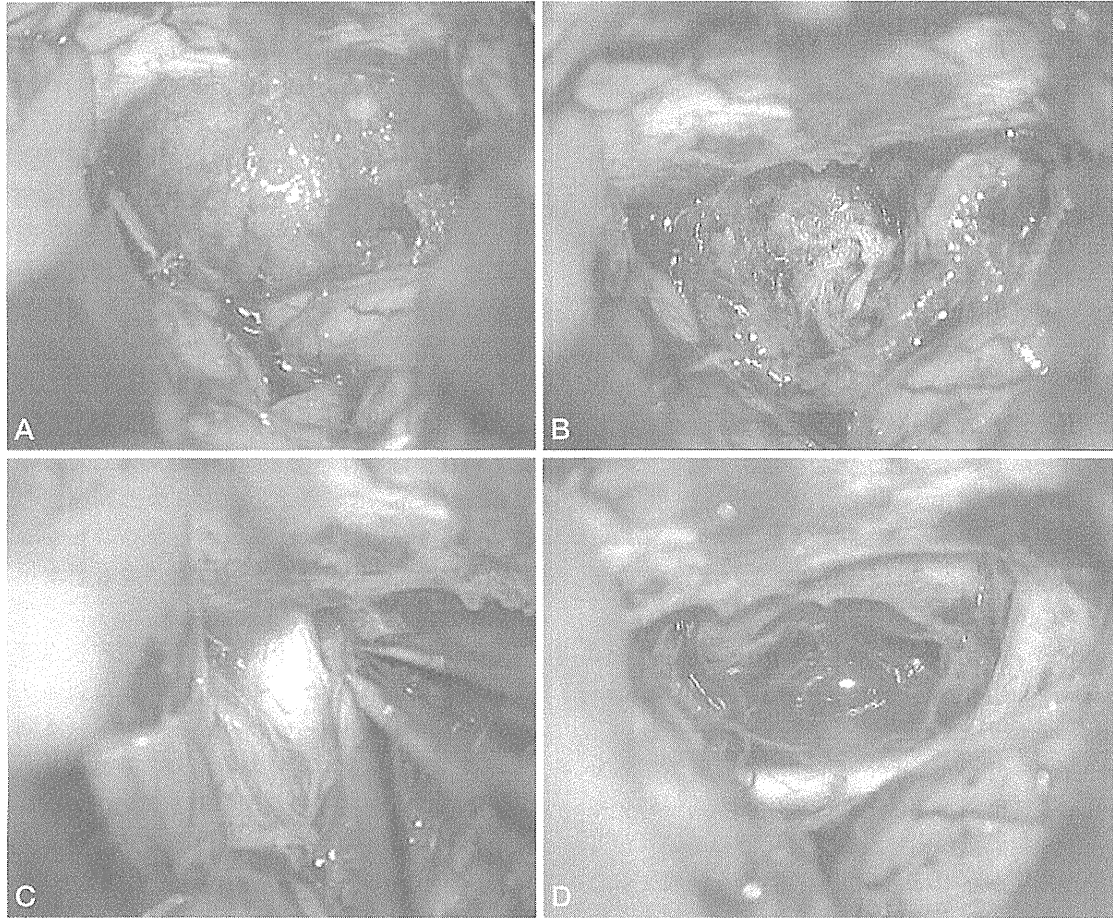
A: After dissection of the anterior interhemispheric fissure, the tumor was exposed in the center of the surgical field. B: The tumor was first detached from its origin with bipolar cautery and debulked with an ultrasonic aspirator. During this step, main tumor feeders from the posterior ethmoidal artery and the superior hypophyseal artery were interrupted in most patients and devascularization of the tumor was also accomplished. C: The side of the optic nerve with better visual function was first dissected because of a better arachnoid plane. D: The tumor was totally removed while preserving the arachnoid plane and the small vessels.
